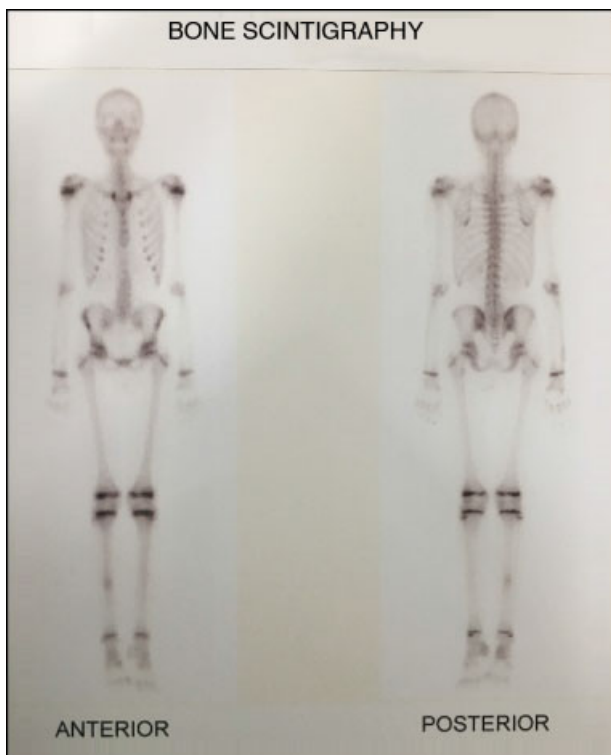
Technetium-99 flow scintigraphy image, with increased uptake in the right tibial diaphyseal region.
